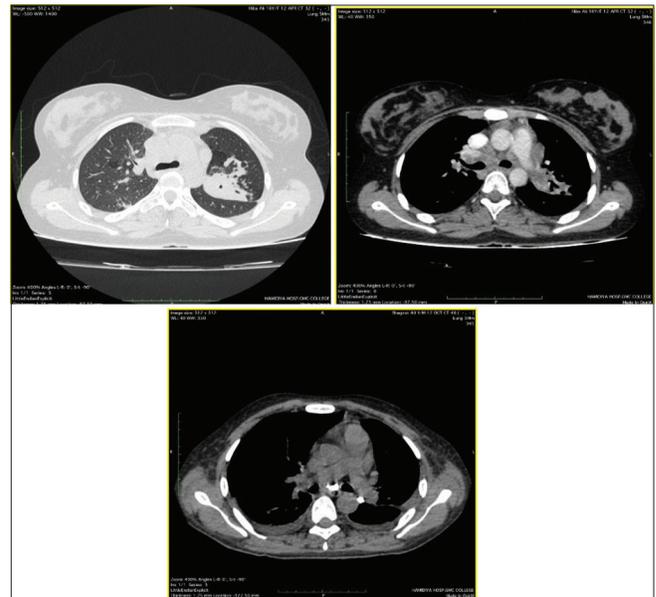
HRCT chest axial sections lung and mediastinal windows in a patient with drug-resistant tuberculosis showing consolidation in anterior segment of the right upper lobe, multiple conglomerated and calcified mediastinal lymph nodes
